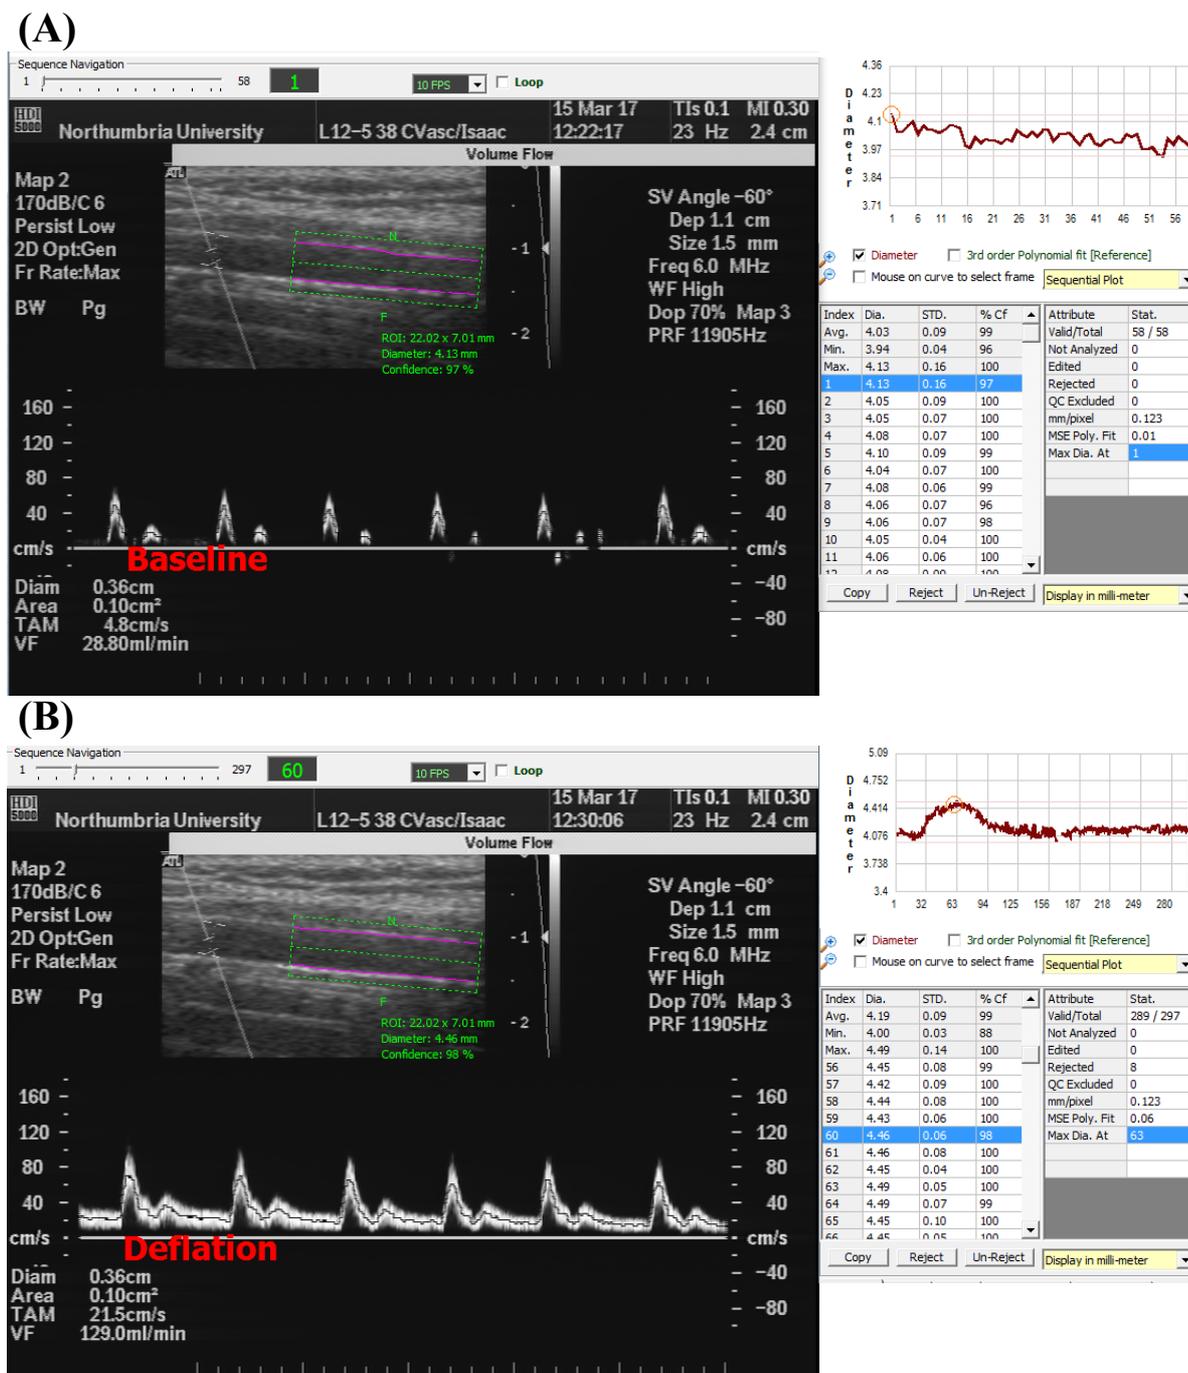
Diameter of brachial artery diameter baseline (A) and deflation (B) acquired with the ultrasound in a young healthy man.
